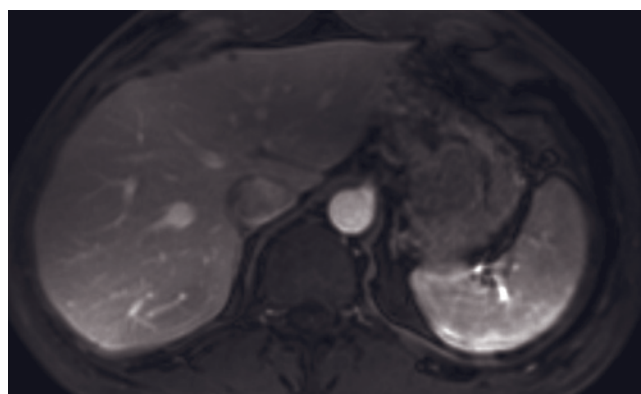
(Continued) single-shot echo-train spin-echo (*i*), T1-weighted out-of-phase SGE (*j*), and T1-weighted postgadolinium hepatic venous phase fat-suppressed 3D-GE (*k*) images demonstrate subserosal GIST (arrows, *b, j*) arising from the lesser curvature in another patient. The tumor shows high signal on T2-weighted image (*i*), low signal on T1-weighted image (*j*), and prominent enhancement on postgadolinium image (*k*). T2-weighted single-shot echo-train spin-echo (*l*), T1-weighted SGE (*m*), T1-weighted
